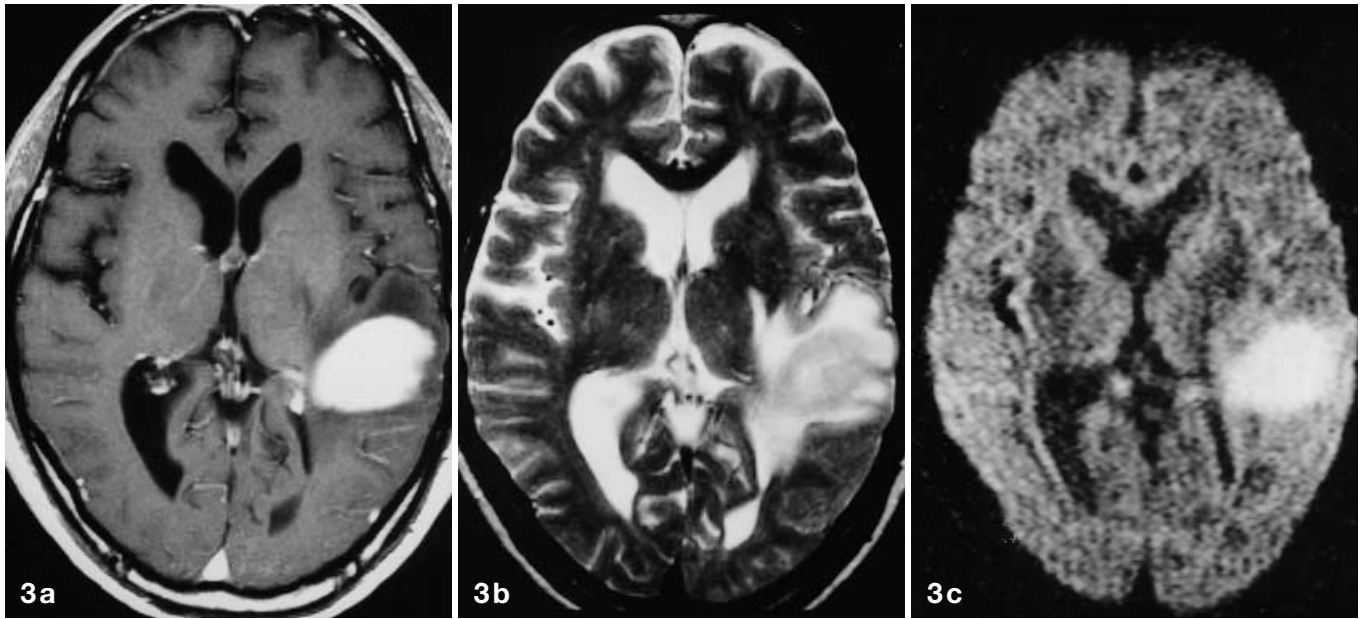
a–c. Type 2. A 68-year-old man with malignant lymphoma. a Postcontrast T1-weighted SE image (TR/TE: 460/12 ms) shows a homogeneously enhancing tumor in the left temporal lobe. A low signal intensity area surrounding the enhancing lesion is seen. The left lateral ventricle is compressed by the tumor. b T2-weighted turbo-SE image (TR/TE: 3000/102 ms) shows a signal intensity in the peripheral portion of the tumor similar to gray matter, and a hyperintense signal of the central portion of the lesion. Perifocal edema is more conspicuously demonstrated as a surrounding hyperintense area. c Diffusion-weighted echo-planar image with a b value of 1200 s/mm^2 shows a homogeneously and markedly hyperintense tumor. Signal intensity of the perifocal edema is isointense to gray matter
